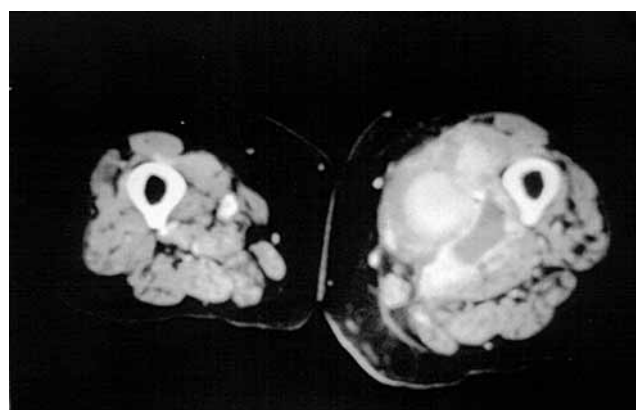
CT scan showing a ruptured superficial femoral artery aneurysm.
